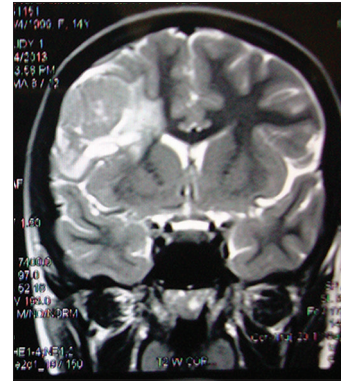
Magnetic resonance imaging showing revealed 4 cm × 3 cm × 2.6 cm right frontal mass showing contrast enhancement
